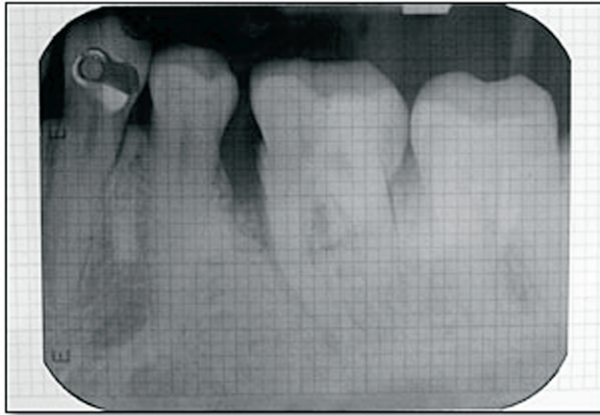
A preoperative periapical radiograph of a vertical defect near tooth #19 in a film mount with a millimeter grid scale.
